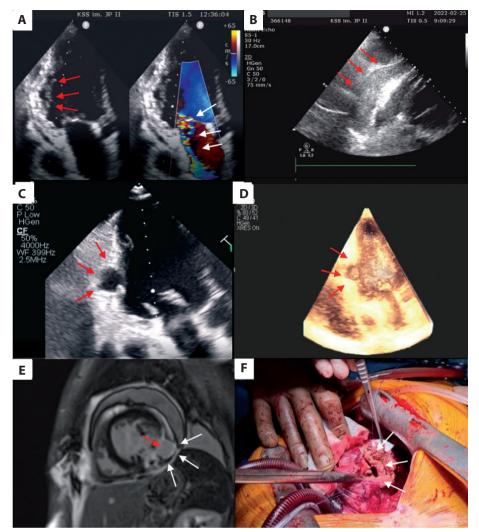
A. Akinesis and a small indentation in the posterior wall (red arrows) and moderate to severe mitral regurgitation (white arrows). B. Pericardial effusion (red arrows). C. D. Dyskinetic thin-walled cavity measuring 25 × 20 × 15 mm (TTE 2D, TTE 3D) (red arrows). E. Aneurysm in the inferolateral wall (red arrow) due to ischemic transmural damage — LGE T1-weighted image (white arrows). F. Left ventricular free wall rupture (white arrows) during operation
